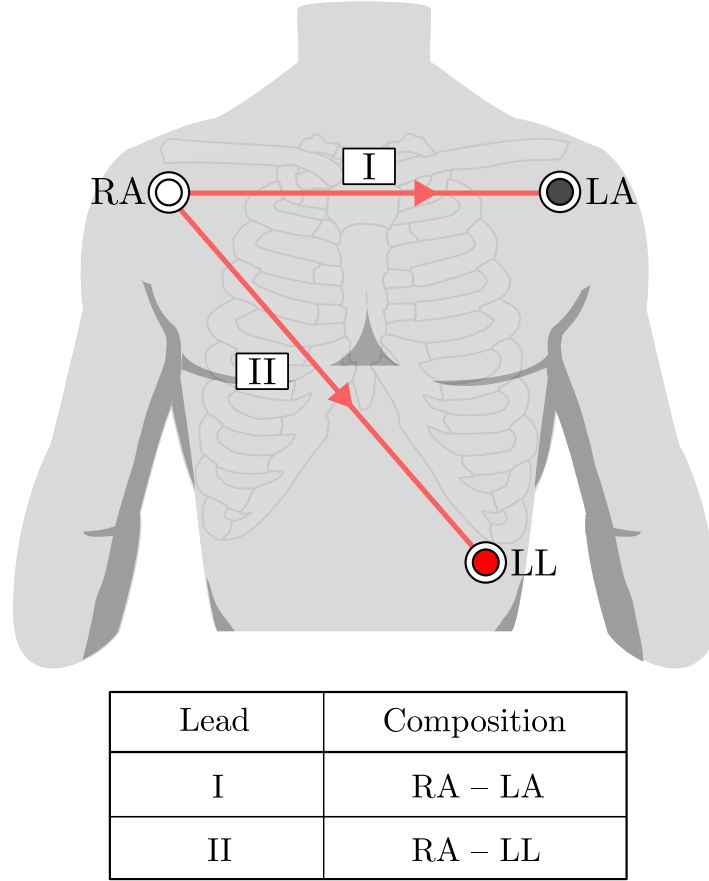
Common electrode locations for bipolar IPG measurement covering both transthoracic and transdiaphragmatic planes of the body. Redrawn from Redmond (2013) by author.
